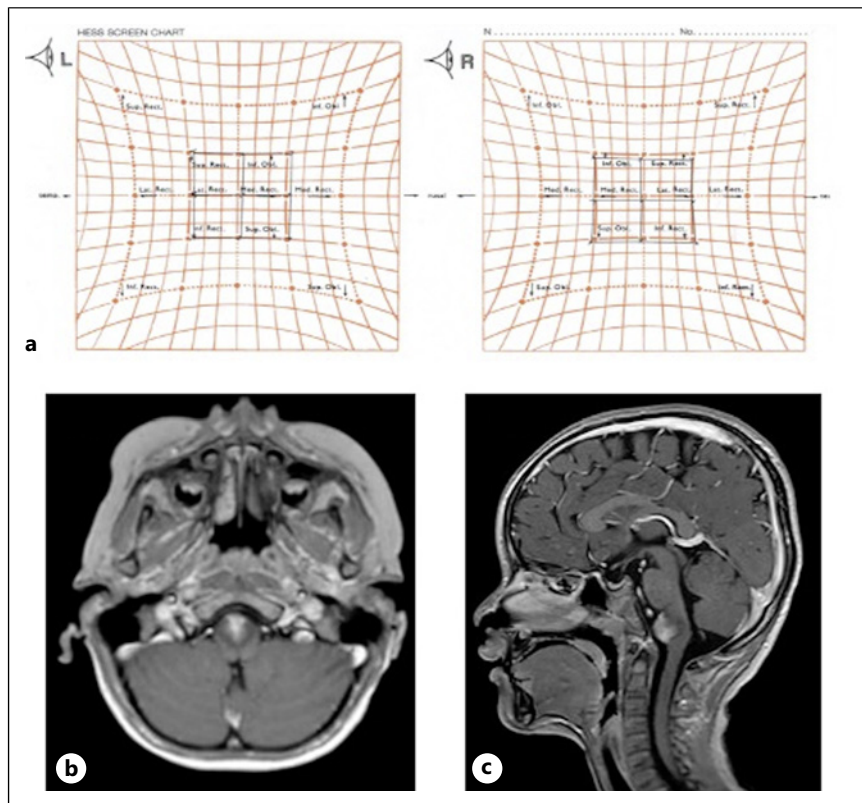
Hess red-green test record and magnetic resonance image (MRI) of the brain in case 2. a Hess red-green test record. Showing visual fields of equal size with the record conducted under 40Δ base-out prism neutralization. Axial plane (b) and sagittal plane (c) Gd contrast-enhanced MRI of the brain. Showing a 16 mm × 18 mm mass protruding ventrally from the medulla oblongata on T1-weighted image. The border is indistinct, and the interior is heterogeneous.
